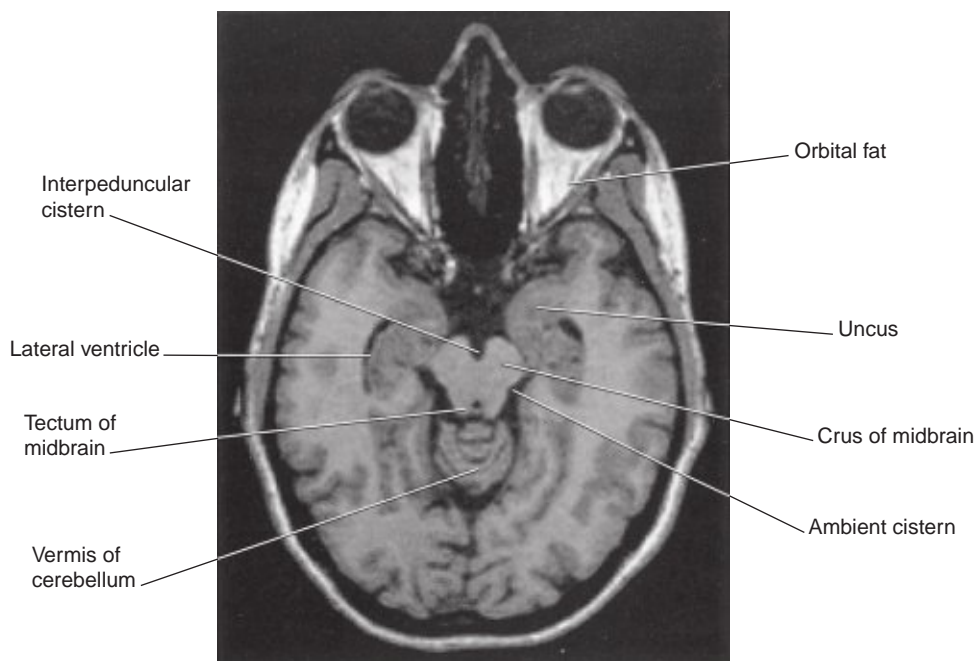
Horizontal MRI. Note the proximity of the uncus to the crus of the midbrain (cf. uncal herniation, Clinical Panel 6.2). (From a series kindly provided by Professor J. Paul Finn, Director, Magnetic Resonance Research, Department of Radiology, David Geffen School of Medicine at UCLA, California, USA.)
